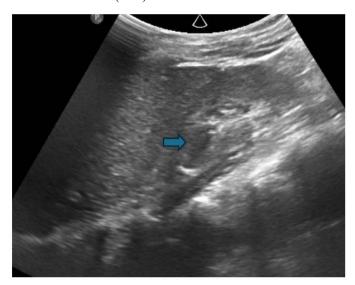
Ultrasound image of the right kidney showing a triplex collecting system () with focal upper moiety caliectasis. An increased parenchymal echogenicity and loss of corticomedullary differentiation.
